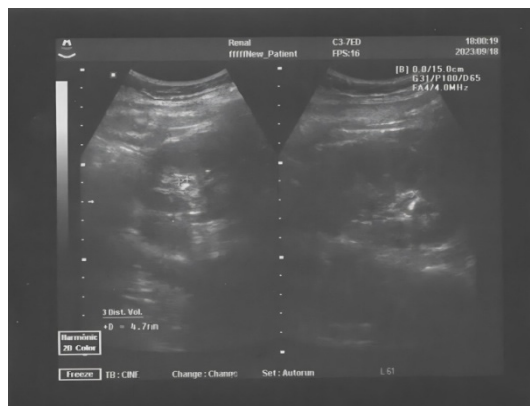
Patient G. Ultrasound of the kidneys from September 20th, 2023. The presented images show microliths in the upper and lower calyces of the right and left kidney
